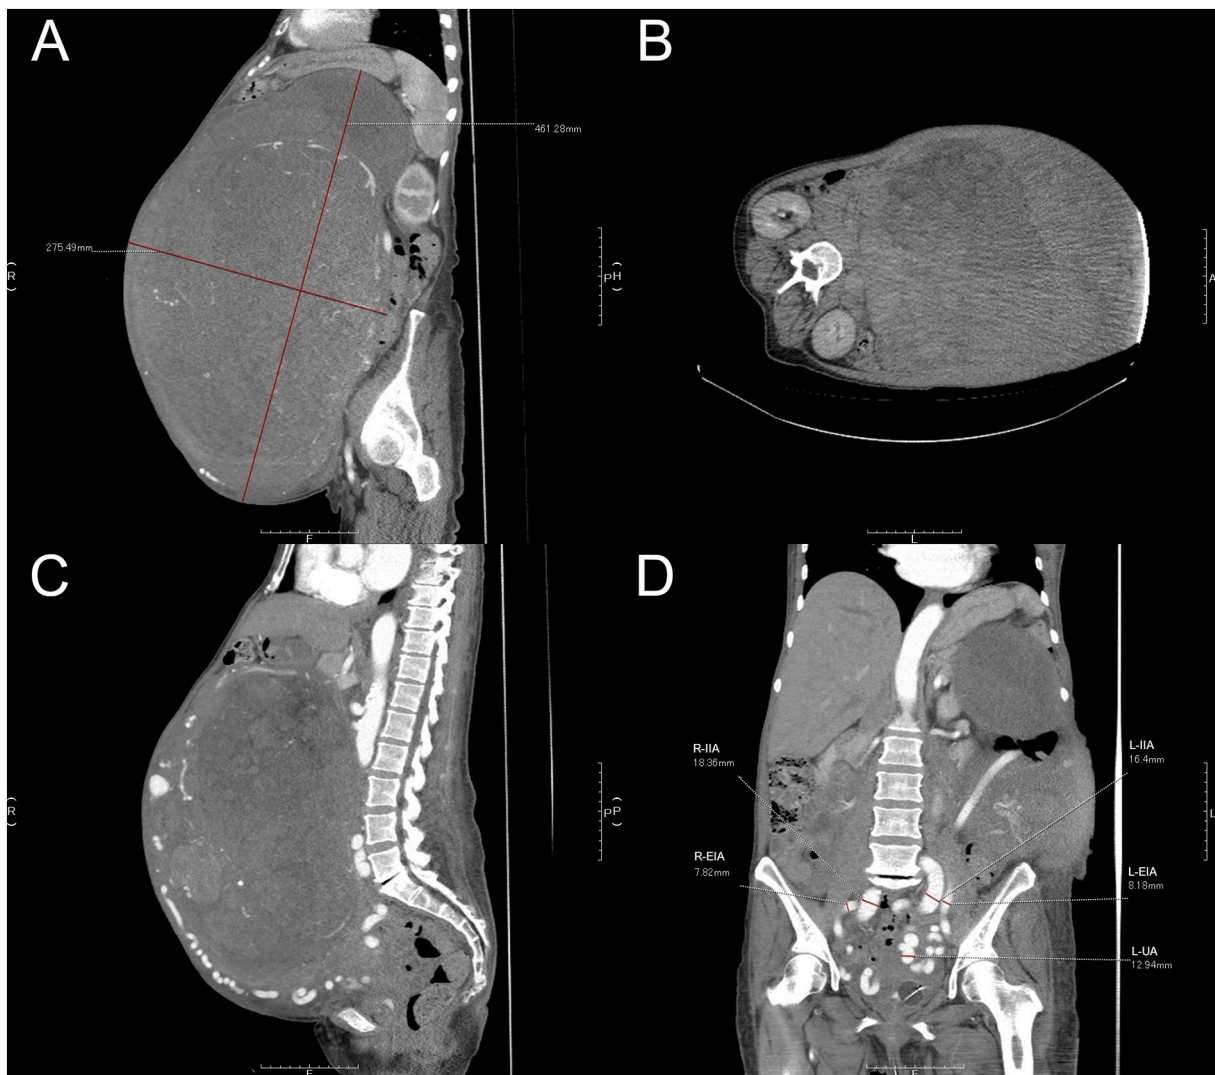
Computed tomographic findings. (A) The maximum diameter of uterine leiomyoma exceeded 46 cm. (B) The giant uterine leiomyoma had prolapsed completely outside the pelvis. (C) The feeding vessels of uterine leiomyoma were very thick and irregularly distributed. (D) The internal iliac artery had a diameter more than twice that of the external iliac artery, and the diameter of the uterine artery was 1.3 cm. R-IIA, Right internal iliac artery; R-EIA, Right external iliac artery; L-IIA, Left internal iliac artery; L-EIA, left external iliac artery; L-UA, left uterine artery.
